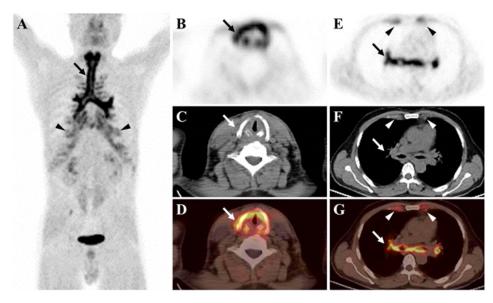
To identify any relevance to a malignant tumor and delineate the extent of the lesions, ¹⁸F-fibroblast-activation protein inhibitor (FAPI) PET/CT was performed three days later as a part of clinical trial approved by the institutional review board in our institution. The MIP image (A, arrow) showed more intense uptake in the laryngeal cartilage and tracheobronchial tree. The SUVmax of laryngeal cartilage (B, C and D, axial PET, CT and fused PET/CT image, arrow) and tracheobronchial tree (E, F and G, axial PET, CT and fused PET/CT image, arrow) were from 8.8 to 10.0. Besides, all costal cartilages (arrowheads in A, E, F and G) showed intense and symmetrical ¹⁸F-FAPI uptake, the SUVmax being 5.1.
